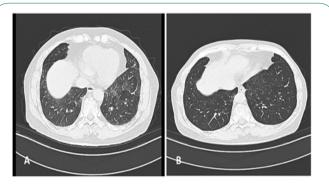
Imaging abnormalities that do not represent interstitial lung abnormalities (false ILA): A 69 years old male, CT images in 2017year (A): CT showed Ground-glass shadow with air retention; in 2021 year (B): the abnormality disappeared.
